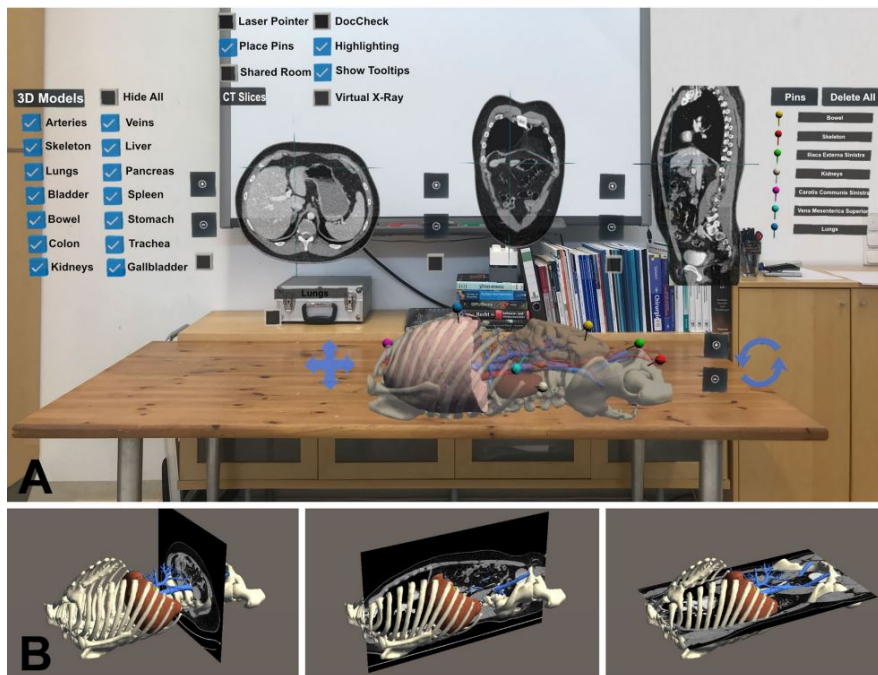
Overview of the VesARlius system. A) The different components of the VesARlius user interface; B) Computed tomography (CT) section images placed within the virtual 3D model. (From [10])
